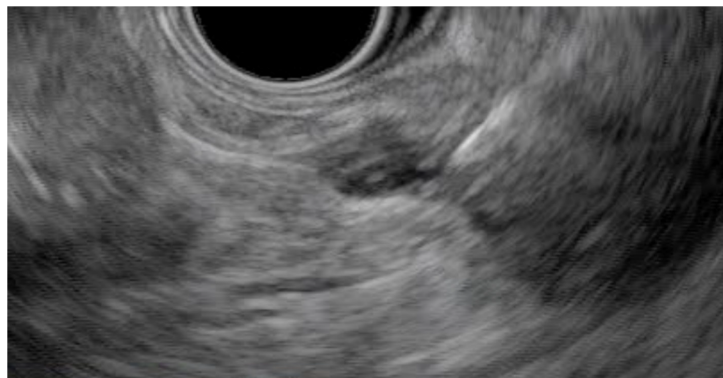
Endosonographic image of the microforceps bite of the wall tenting tissue within a pancreatic cystic lesion.
